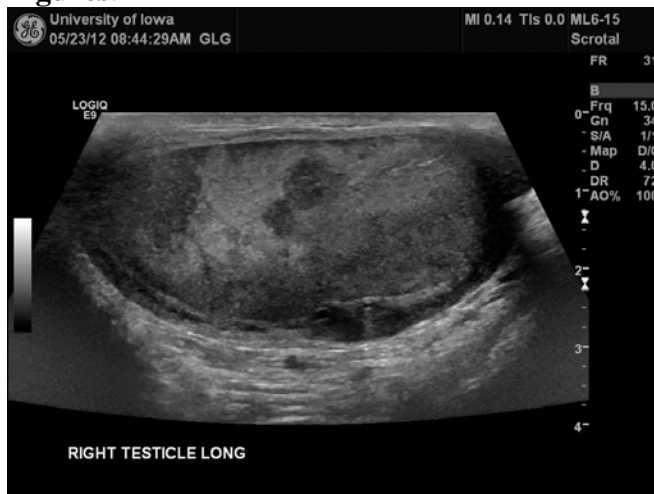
Grayscale ultrasound images of the right testis showing multiple hypoechoic areas suspicious for malignancy.
